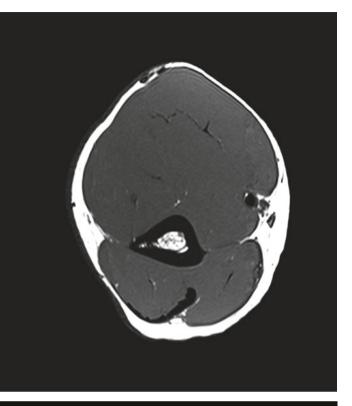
MRI scans at the proximal third of the arm through the musculocutaneous nerve
